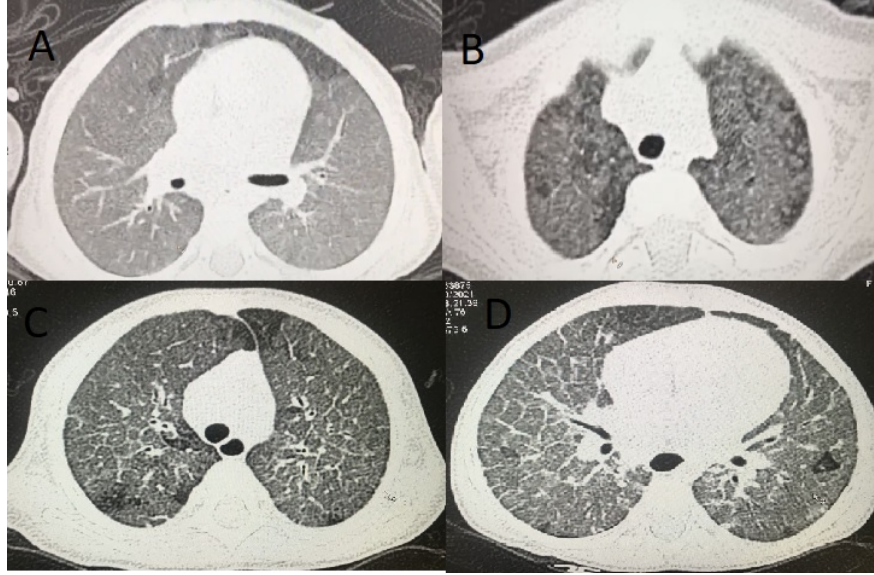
Thorax high resolution computed tomography (HRCT) images. A and B-First HRCT at 14mo showed extensive diffuse ground-glass opacity in both lungs. C and D- HRCT at 17mo detected ground-glass opacities affecting both lungs, with the appearance of septal thickening and diffuse thickening of the bronchial walls.
